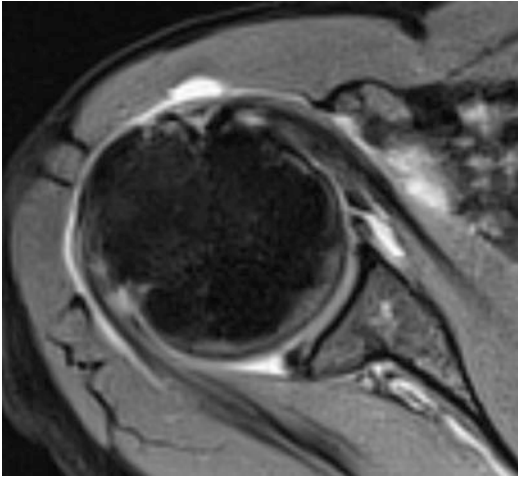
MRI in transverse plane showing enlargement and edema of subscapularis tendon consistent with tendinosis
